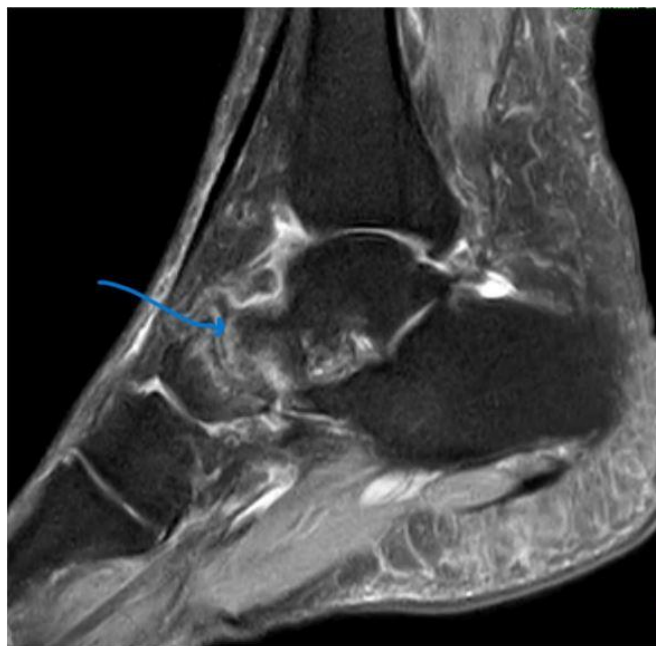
shows MRI of the right ankle in a 52 years old female patient who presented with right ankle pain. The Sagittal Short tau inversion recovery (STIR) image reveals a subchondral hyperintense signal with marginal erosions (blue arrow) along the articular surface with loss of articular cartilage at talonavicular joint consistent with Rheumatoid arthritis.
